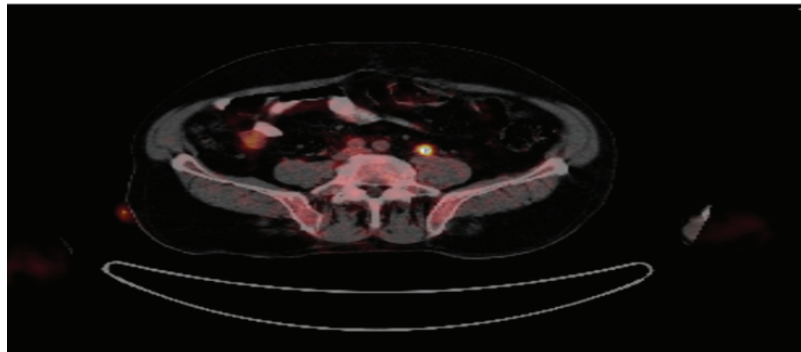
Posttreatment PET-CT.
